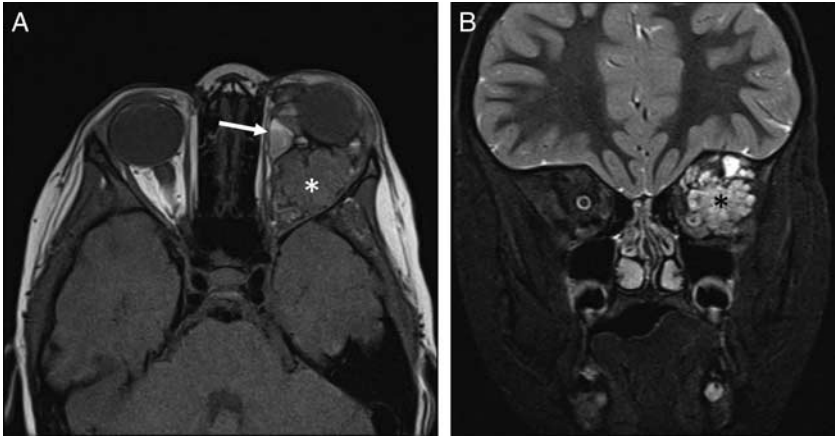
2-year-old boy presented to ophthalmologist with 6 months of progressive proptosis and was found to have a venous lymphatic malformation. Axial T1-weighted noncontrast MRI (A) demonstrates a predominantly T1 isointense mass with fluid-fluid levels (white arrow) centered in the left intraconal space extending into the medial and superior extraconal spaces. This results in mild proptosis (white asterisk). Coronal T2-weighted MRI demonstrates a heterogeneous T2 hyperintense multispatial retrobulbar mass (B, black asterisk). MRI indicates magnetic resonance imaging.
